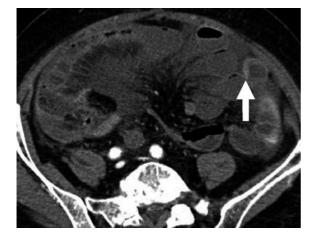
Strangulating small bowel volvulus 5 weeks after surgery for rectum prolapse in a 76-year-old female, contrastenhanced CT. Mesenteric fat stranding and ascites indicate primarily compromised venous drainage. The wall of obstructed small bowel loops shows varying degrees of thickening and attenuation. Wall hyperattenuation from intramural hemorrhage and/or hyperenhancement from hyperemia (*arrow*) is seen in venous occlusion. In other bowel loops the enhancement is decreased or absent. Radial array of mesenteric vessels converging toward the point of torsion. Surgery confirmed ischemia and infarction of the ileum secondary to an adhesive band
